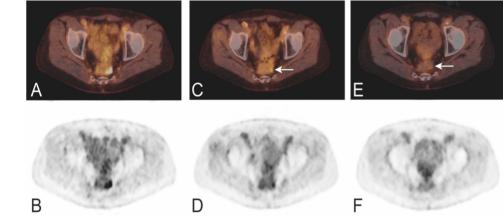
Response monitoring neoadjuvant treatment local recurrence. Representative PET/CT and PET images before treatment (A, B), after neoadjuvant chemotherapy (C, D) and after neoadjuvant chemoradiation (E, F) are depicted.
